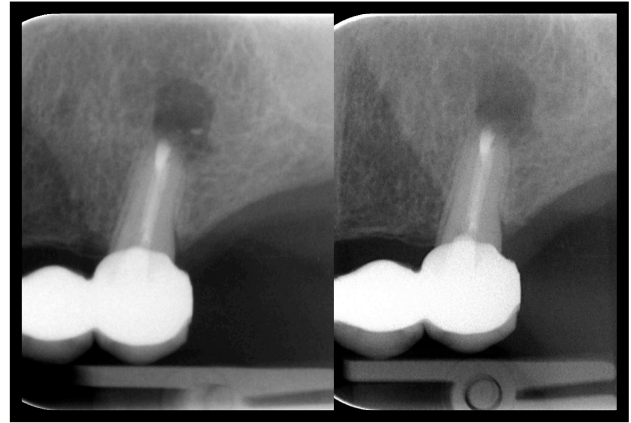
Left: Peroperative, Right: Postoperative radiograph, 1. Mar. 2012
